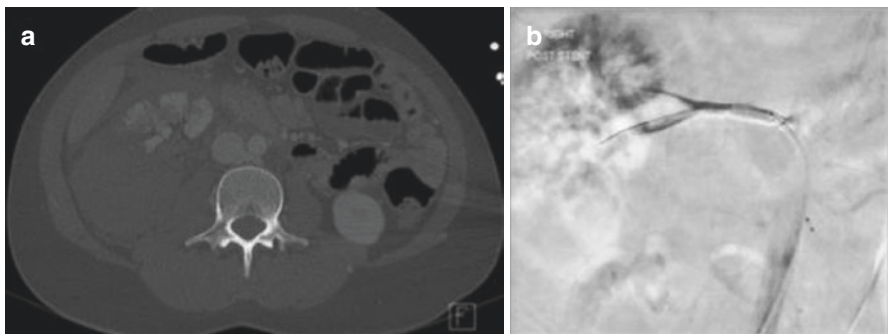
(a) Axial CT showing retroperitoneal tamponade. (b) Fluoroscopy during right segmental renal artery embolization (Images: Mr. D Sharma)
